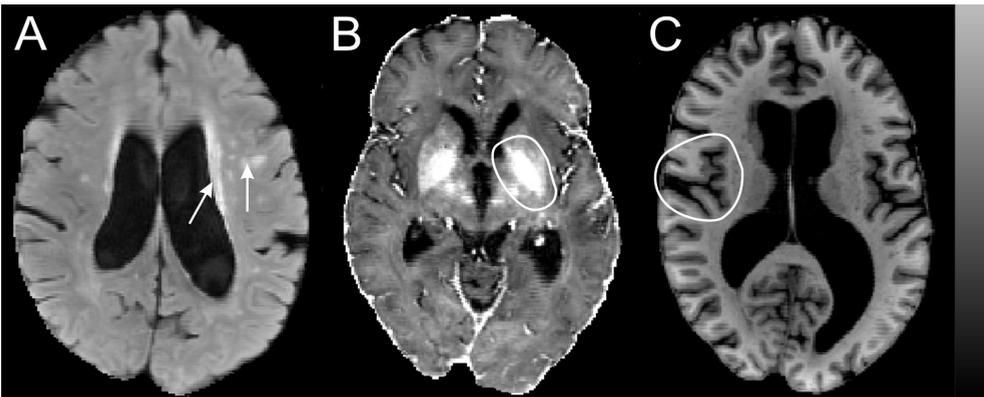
(A) T2-FLAIR, (B) R2* maps calculated from T2*-weighted gradient-echo (GRE) and (C) MPRAGE images showing structural brain status. White matter signal abnormalities and iron accumulation appear bright (i.e., hyperintense) on the T2-FLAIR image and the R2*-weighted gradient-echo image, respectively. The MPRAGE shows a decrease in brain volume and ventricular enlargement.
